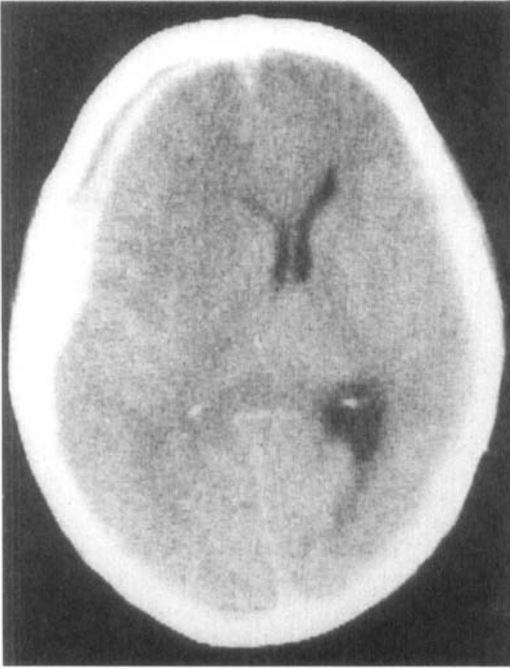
Case 1: CT scan showing R sided subdural haematoma with brain shift.
